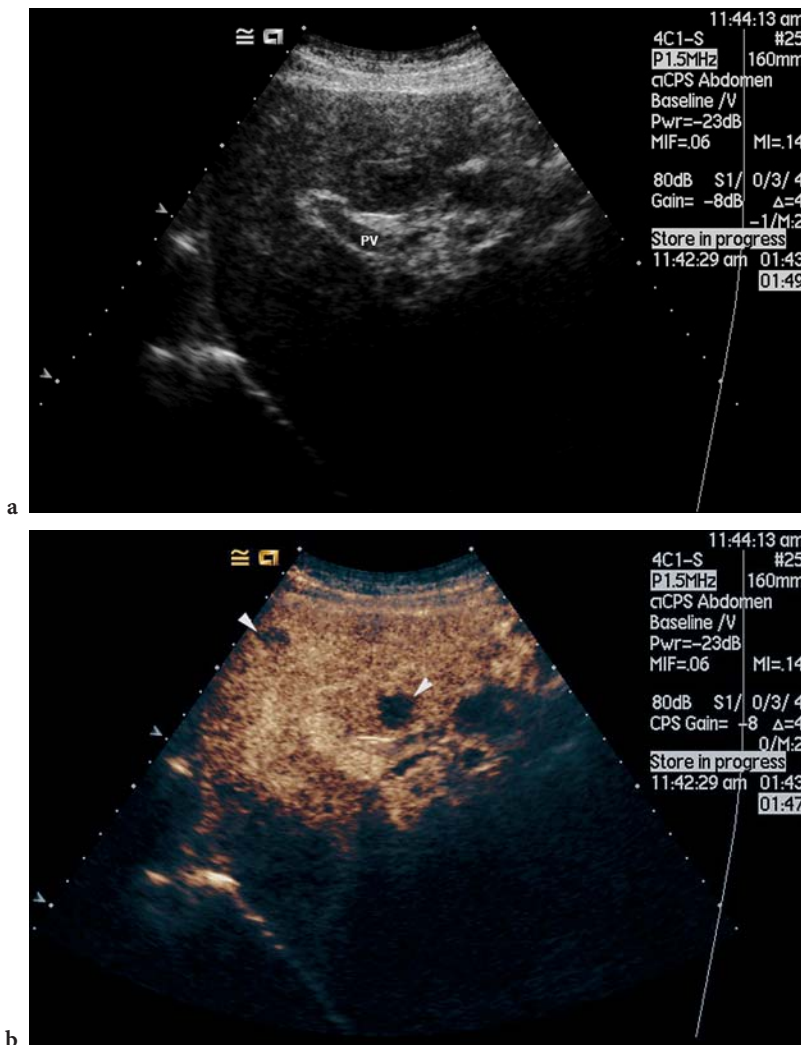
a The staging liver ultrasound in this patient with a gastric carcinoma revealed a slightly irregular texture but no definite focal lesion. b In the sinusoidal (late) phase, almost 2 min after injection of 2.4 ml of the microbubble contrast agent SonoVue, several signal-free foci representing metastases were detected (arrowheads). The mode used was Contrast Pulse Sequences (CPS) which detects the presence of microbubbles whether stationary, as in the liver sinusoids shown here, or moving, as in the portal vein (PV). It operates at low transmit powers – an MI of 0.2 was used in this study – so that microbubble destruction is minimised
